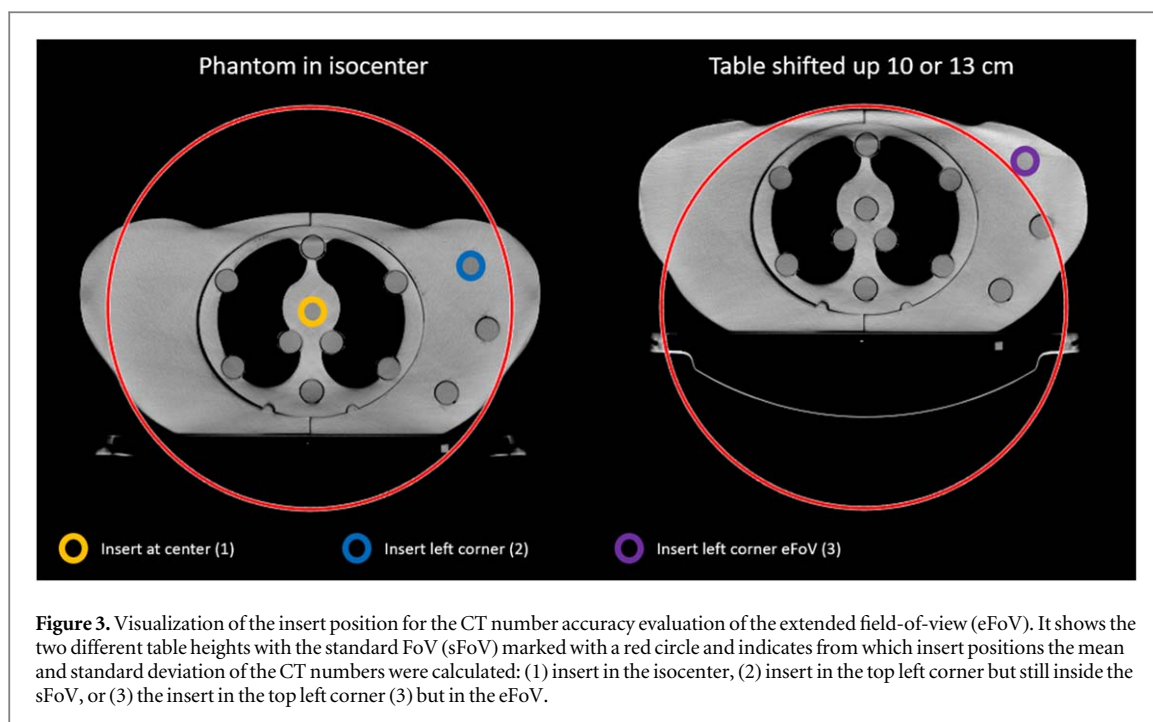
Visualization of the insert position for the CT number accuracy evaluation of the extended field-of-view (eFoV). It shows the two different table heights with the standard FoV (sFoV) marked with a red circle and indicates from which insert positions the mean and standard deviation of the CT numbers were calculated: (1) insert in the isocenter, (2) insert in the top left corner but still inside the sFoV, or (3) the insert in the top left corner (3) but in the eFoV.
